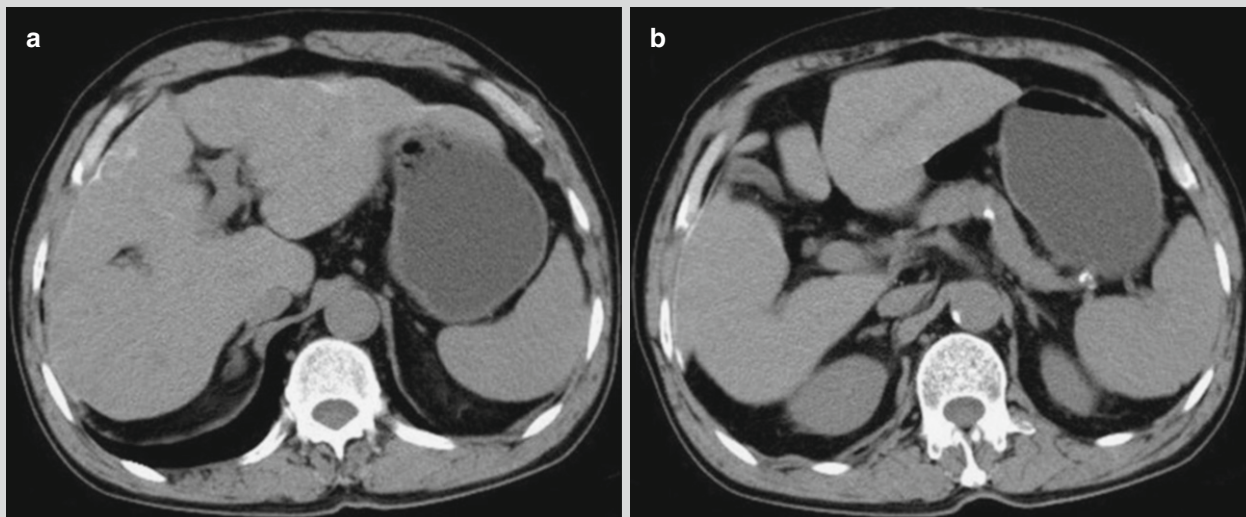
Hepatic schistosomiasis. (a, b) Plain CT scanning demonstrates deformed liver, calcification of Glisson's capsule, and mild splenomegaly
